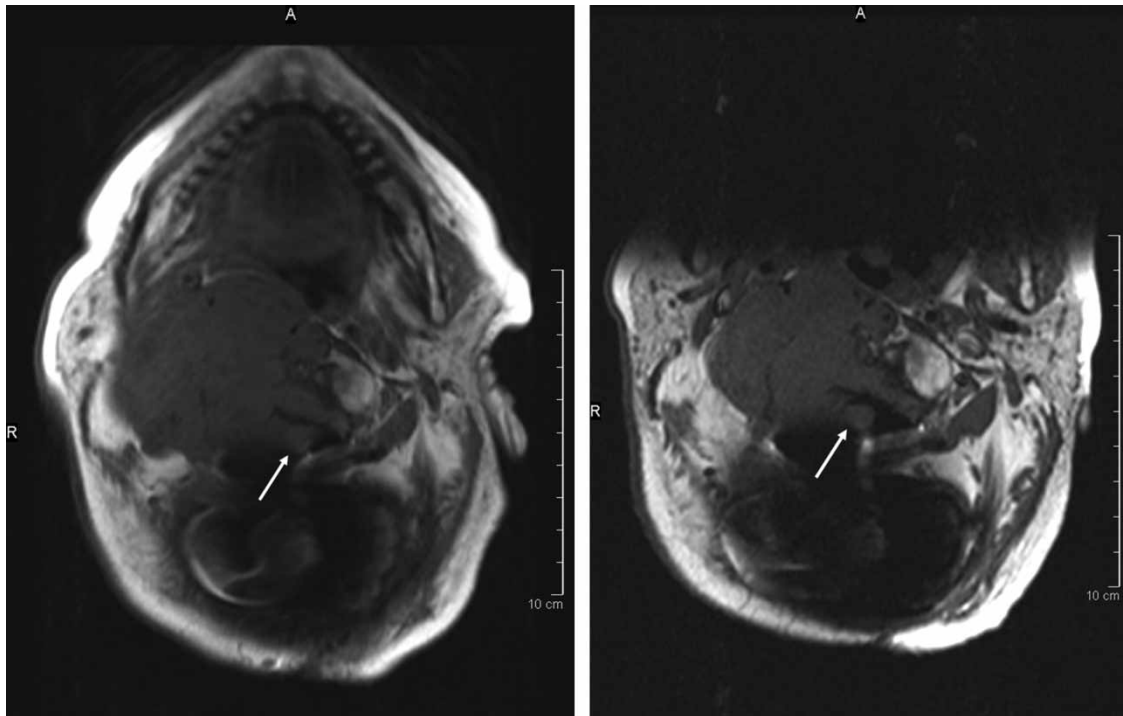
MRI scan of the tumour before and after treatment with cetuximab and gefitinib. The arrows indicate the spinal cord.
